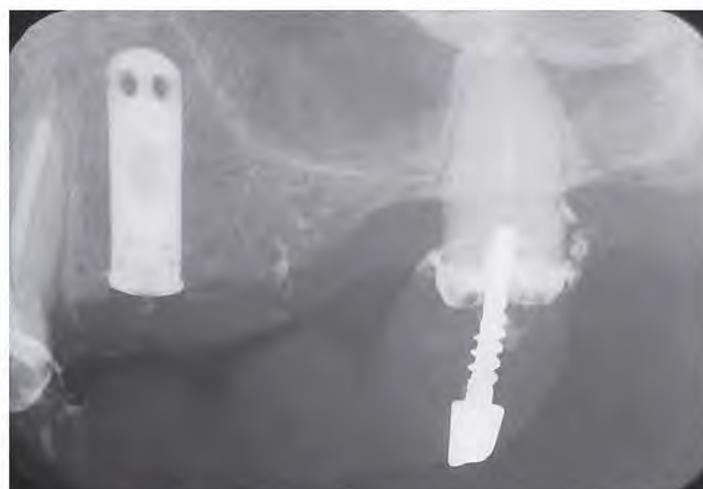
A postoperative radiograph shows proper implant placement and good osseous support.
